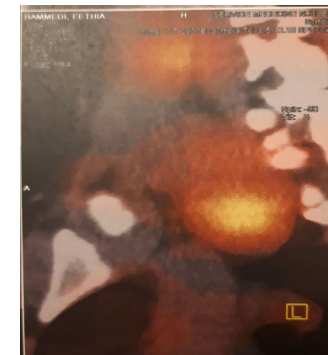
SPECT-CT IMAGES: CT images (b) and SPECT-CT fusion images (c) in sagittal section show that the focus of hypercaptation in the right laterotracheal 131 represents a tissue mass suggestive of metastatic adenopathy
